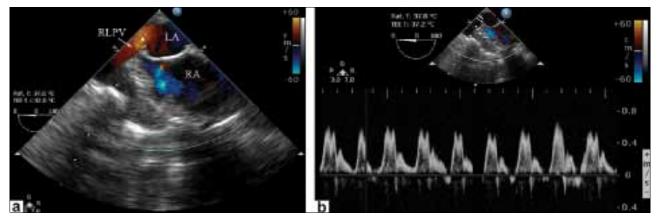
Mid-esophageal view in a patient operated for IVC type of sinus venosus ASD with PAPVC of RLPV showing (a) intact patch and re-routed RLPV (arrow) to LA (b) pulsed wave Doppler to confirm RLPV
